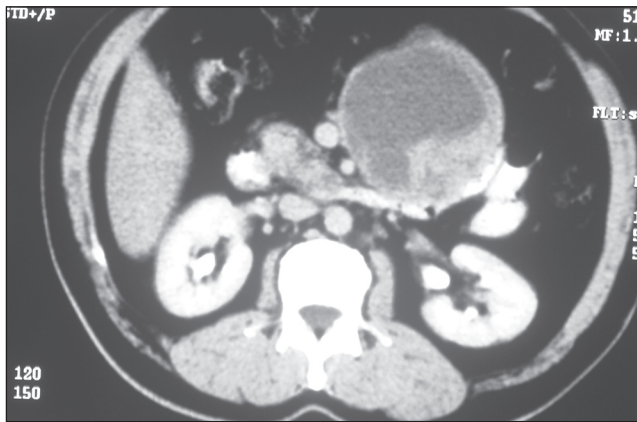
CT of the abdomen: Enhancing solid component in the periphery of the cyst
